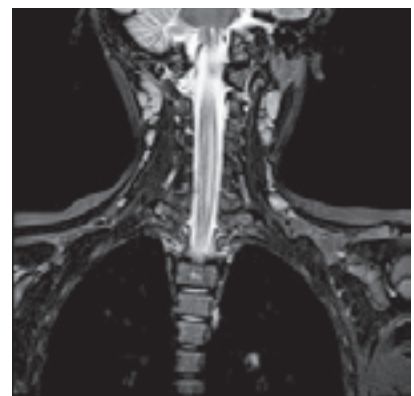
MRI T2-weighted sagittal view of cervicothoracic region revealing T2/FLAIR hyperintensity in the cervical cord between C2 and T1.
